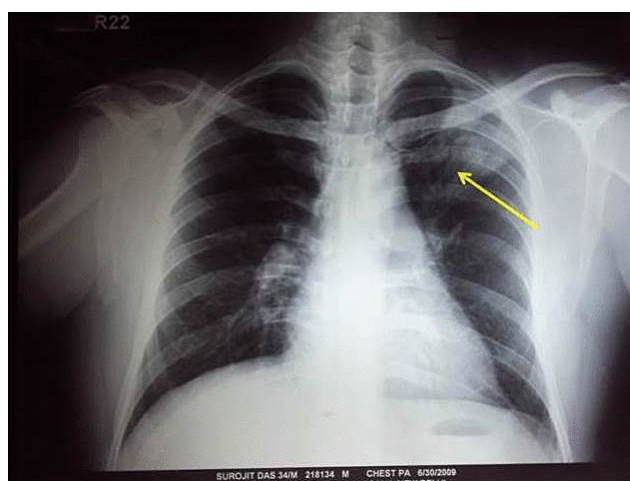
Chest x-ray showing opacity in upper zone of left lung
